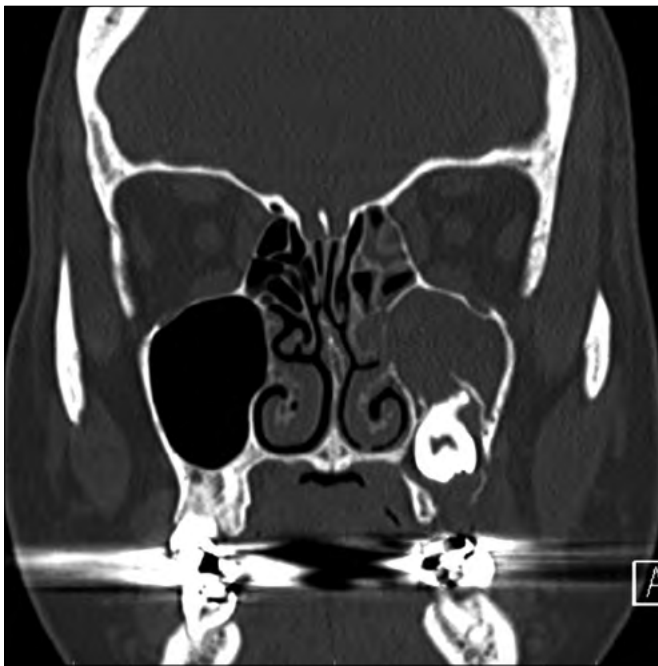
Coronal CT image showing unerupted teeth which determined a sinusitis process involving the ipsilateral maxillary sinus, ostiomeatal complex and, partially, anterior ethmoid sinus. Furthermore, the infection progressively led to the formation of oro-antral communication. A combined approach was performed in order to drain and ventilate the involved sinuses via an endoscopic approach and to remove the unerupted teeth and close the oro-antral communication from an intraoral approach.
